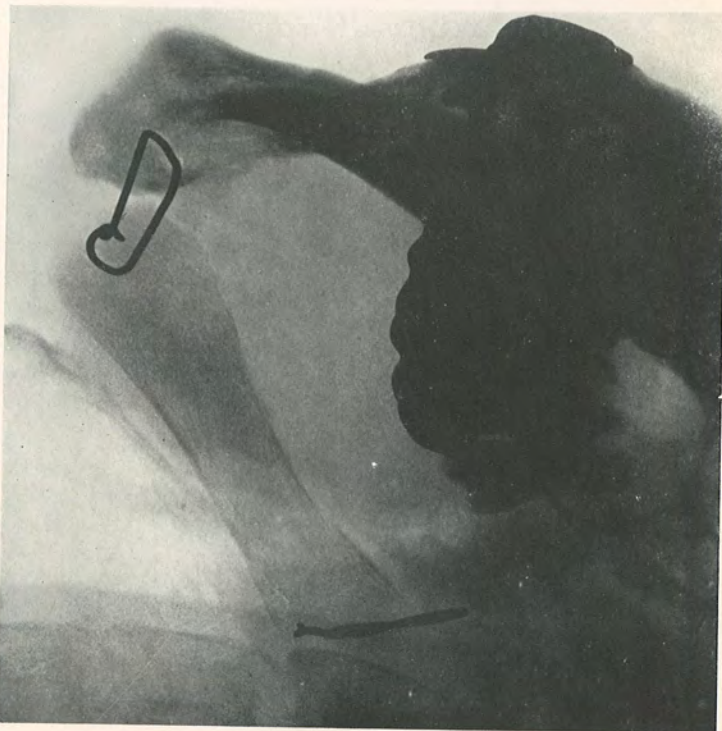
Radiograph made by Dr. H. K. Pancoast, showing graft in place. Clinically, firm union is present, although this is not altogether apparent in the radiograph as far as the anterior end of the graft is concerned.
